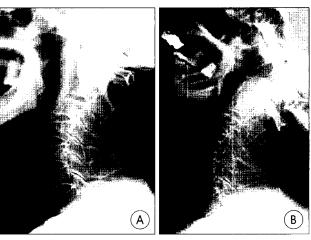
A: Lateral x—ray showing atlantoaxial subluxation. B: Extension lateral radiograph showing full reduction of the subluxation.
